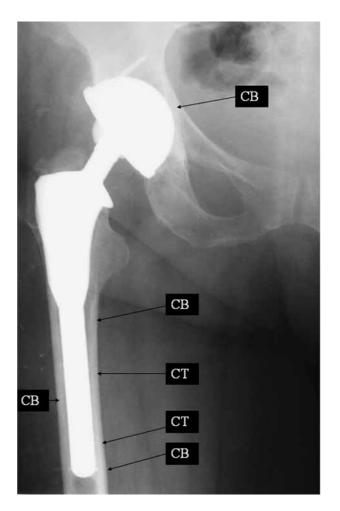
Postoperative anteroposterior roentgenograph, 9 years after total hip arthroplasty with a fully hydroxyapatite – coated total hip implant in a 67-year-old woman, showing good proximal and distal fit of the stem and no signs of resorption. Cortical thickening (CT) at the distal part of the stem is evident and cancellous bone formation (CB) can be demonstrated on the medial, lateral and distal parts of the stem, as well as in all three zones of the acetabular cup. There have been no subsidence or radiolucencies. The patient was assigned a Harris hip score of 96.
